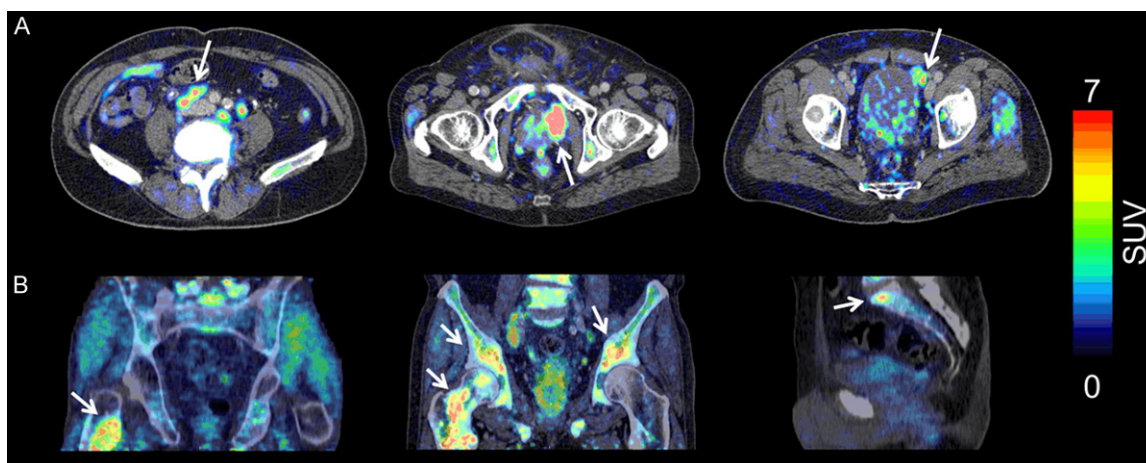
A. Three patients with pathological ¹¹C-donepezil accumulation in lymph nodes. Lymph nodes in the retroperitoneal space (left; SUV_{max} 9.1). Lymph node mass next to the bladder (middle; SUV_{max} 15.8). Single lymph node next to the bladder (middle; SUV_{max} 15.8). B. A representative patient with pathological ¹¹C-donepezil accumulation in suspected, sclerotic bone metastases. Multiple lesions in femoral and pelvic bones (middle; SUV_{max} 11.0 in left acetabulum). [White arrows denote pathological uptake in lymph nodes and bone lesions; yellow arrows denote lymph nodes in A and sclerotic bone lesions in B].
